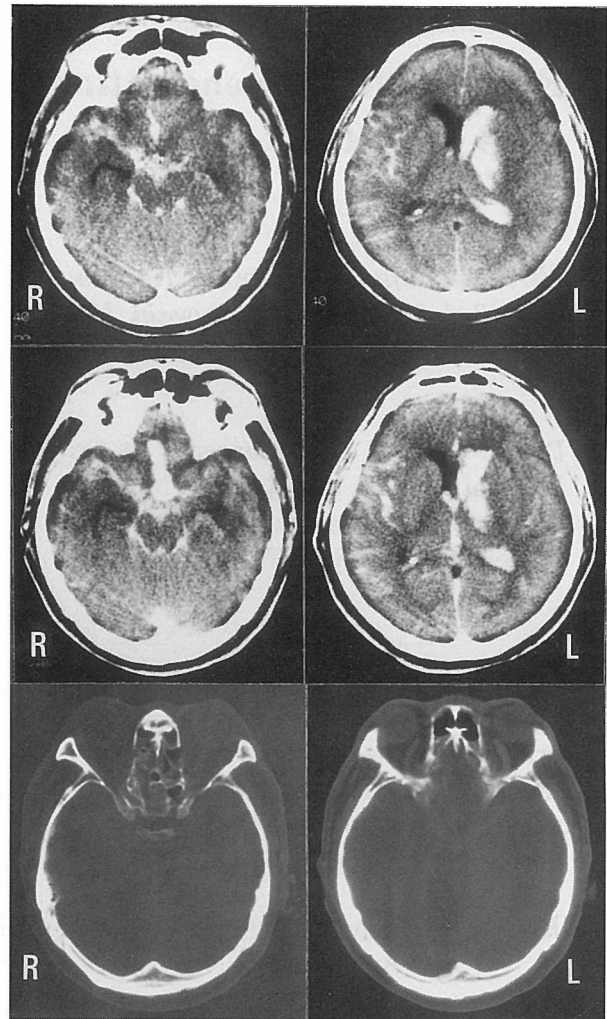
CT scan on admission. A: Precontrast CT scan. Subarachnoid and intraventricular hemorrhage and an intracerebral hematoma are evident. B: Postcontrast CT scan. An area of strong enhancement is seen in the anterior part of the suprasellar cistern extending to the interhemispheric fissure. C: There is bleeding in the bilateral ethmoid sinus, but the fracture at the skull base is not identifiable.
